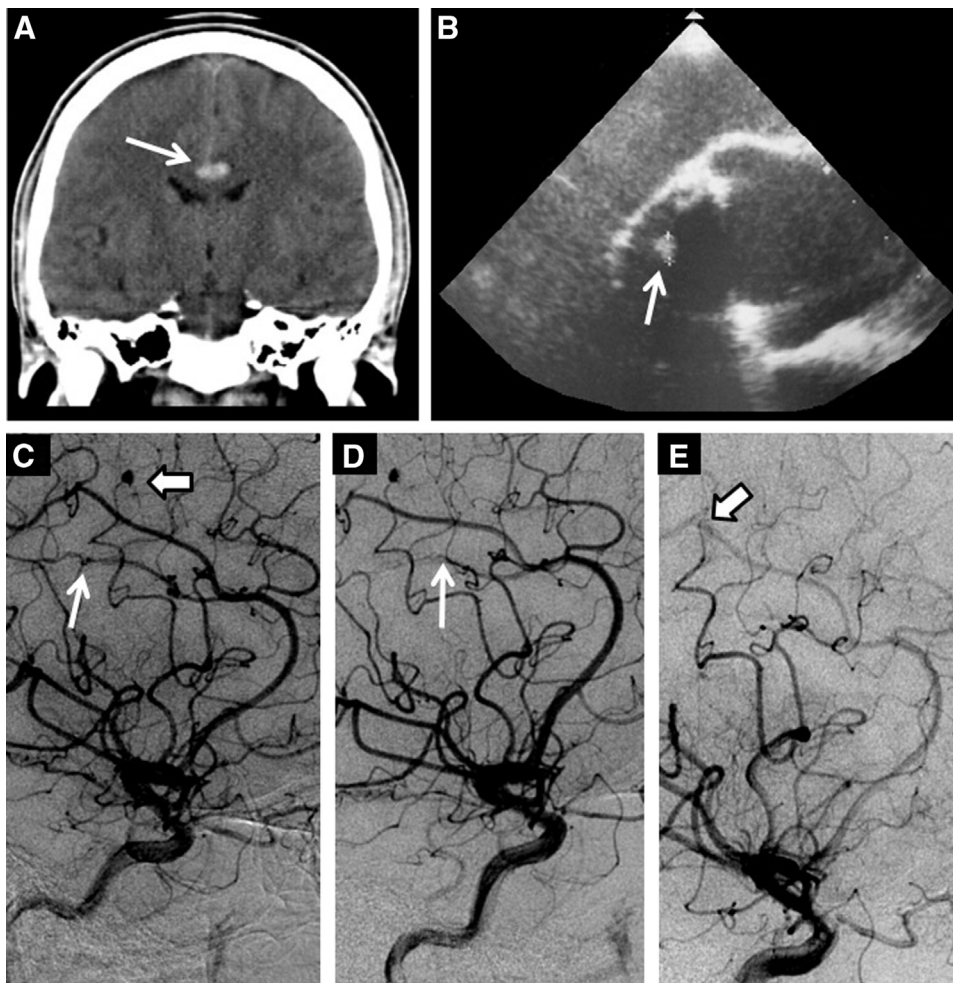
Coronal computed tomography scan of the brain showing subarachnoid hemorrhage in the supracallosal cistern (arrow, A) and transesophageal echocardiography with evidence of vegetation over the mechanical prosthetic aortic valve (arrow, B). Digital subtraction cerebral angiography revealing a ruptured aneurysm of the right pericallosal artery (thin arrow, C) and an aneurysm in the M4 division of the right middle cerebral artery (thick arrow, C). Digital subtraction cerebral angiography showing treatment of the infectious aneurysms with endovascular glue embolization of the parental artery (thin arrow, D and thick arrow, E).
